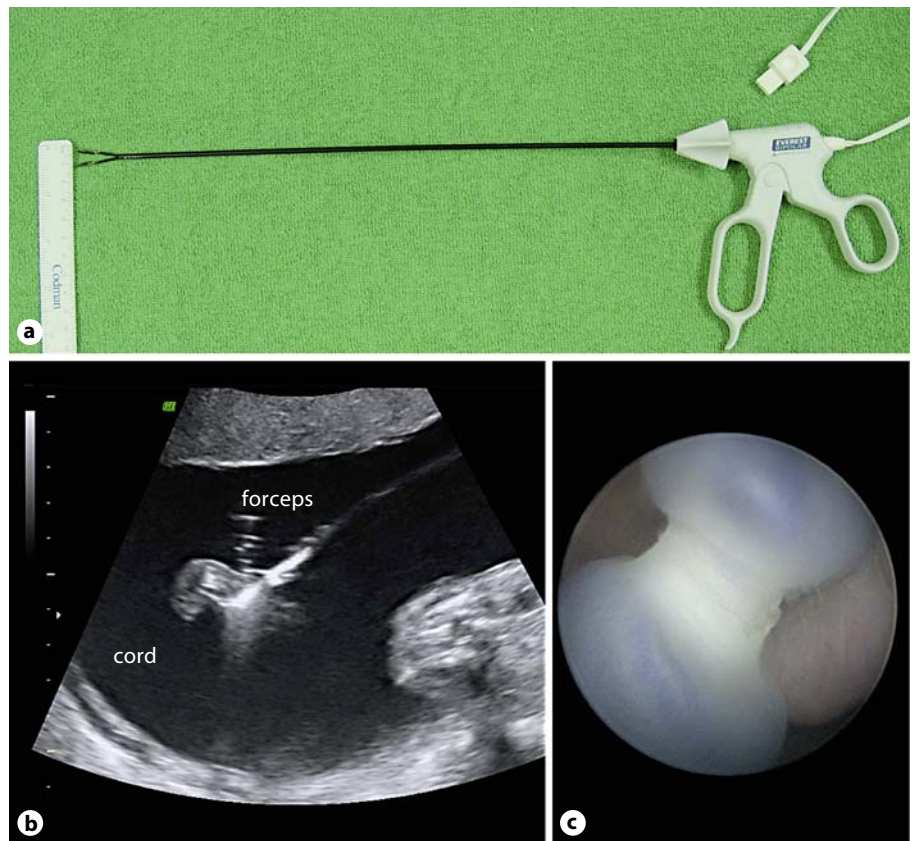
a Disposable bipolar forceps (Everest Medical, Minneapolis, Minn., USA). b Ultrasound image of bipolar cord coagulation with steam bubbles indicative of effective coagulation. c Fetoscopic control to check for completeness of the coagulation: the segment was fully coagulated by bipolar coagulation.
